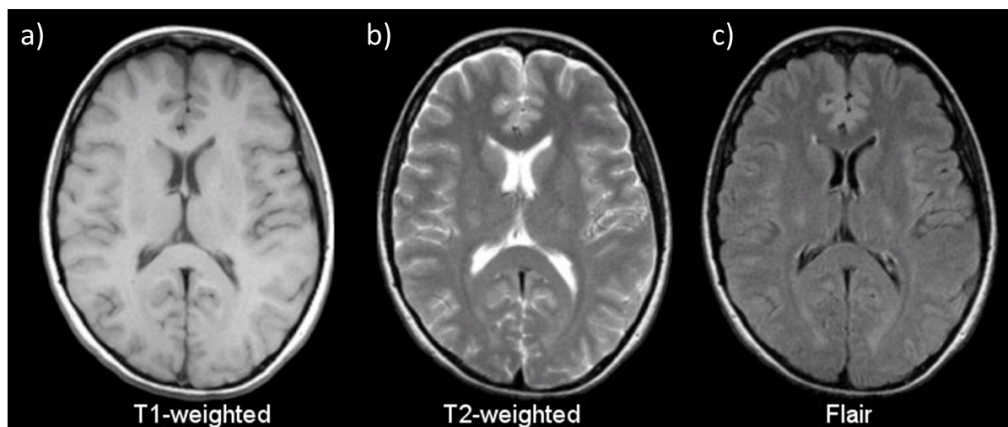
T_1 weighted, T_2 weighted and FLAIR images in the brain showing tissue and fluid contrast in grey matter, white matter and CSF, with CSF suppressed in FLAIR.
